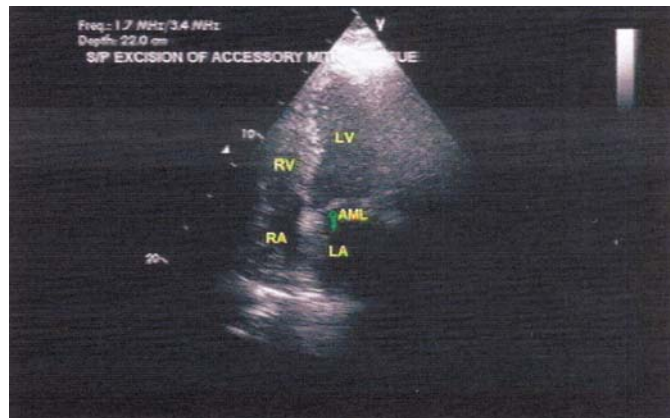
Post operative echocardiography with no residual accessory leaflet
